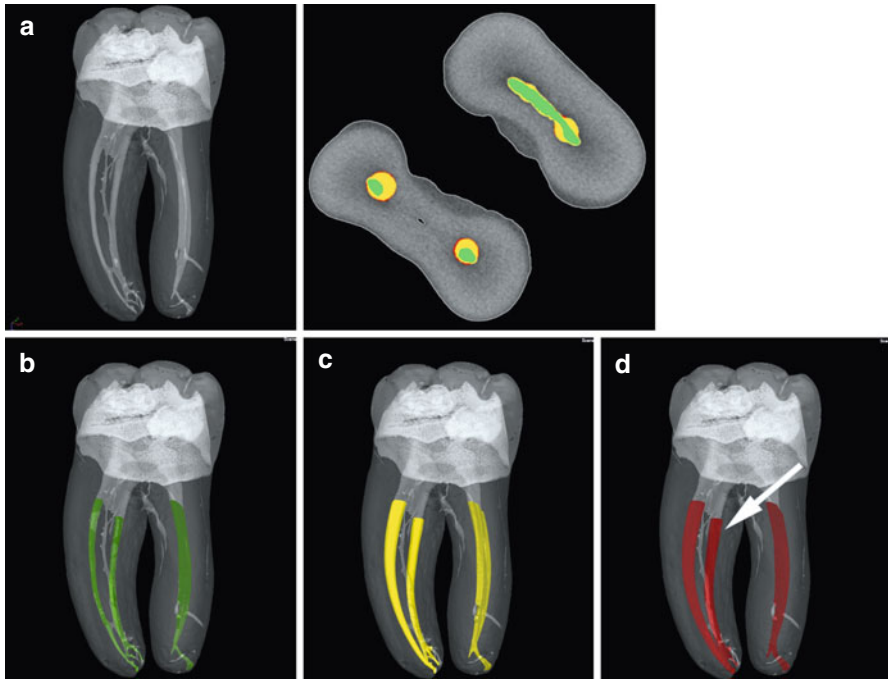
Micro-computed tomography images of molar root canal systems (a). Separate canals are shown before shaping (b, green) and at an apical sizes #20 (c, yellow) and #30 (d, red). Note the different shapes coronally with preservation of coronal structure evident in the canal prepared with TRUShape (Dentsply Tulsa Dental, arrow). Inset shows a cross section in the coronal third with the different stages of canal preparation indicated by colors with the TRUShape-prepared canal to the right in the mesial root, corresponding to images (b–d)
